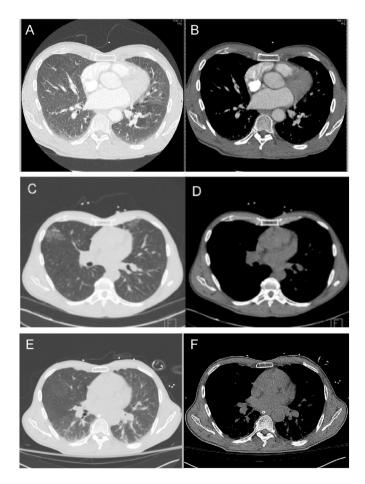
CT angiogram of the chest at hospital days 1, 8, and 13. The CT angiogram (lung window and mediastinal views, panels A &B) on hospital day 1 revealed a borderline large pulmonary artery, two nodules (3 mm and 4 mm) in the right middle lobe of the lung, and emphysematous changes of the lung parenchyma. There was no evidence of large or small vessel pulmonary emboli. Repeat CT chest on hospital day 8 (panels C & D) shows new fluffy peripheral infiltrates in the right upper lobe and lingula. By hospital day 13 (panels E & F) the fluffy infiltrates have resolved but with interval development of some tree and bud findings in the bilateral lower lobes and some small nodules are noted in the lower lobes.
